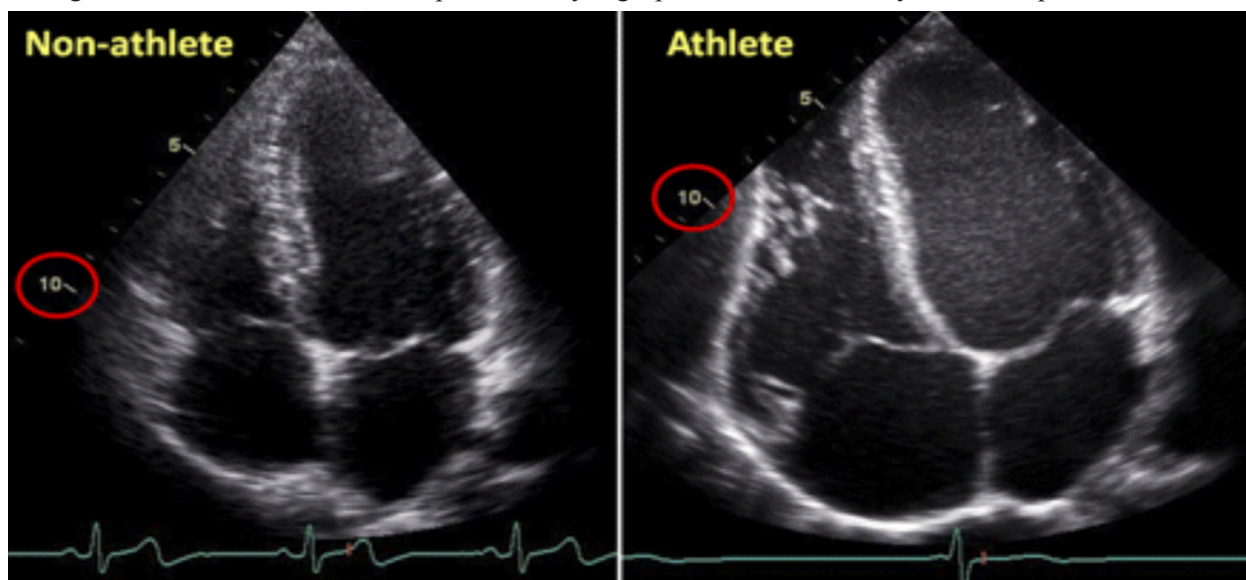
Apical four chamber echocardiogram compares the heart of a 23-year-old non-athlete (left) with that of a 23-year-old professional cyclist. Athletes experience dilation of all four cardiac chambers and an increase in stroke volume, despite normal or even reduced resting function.
